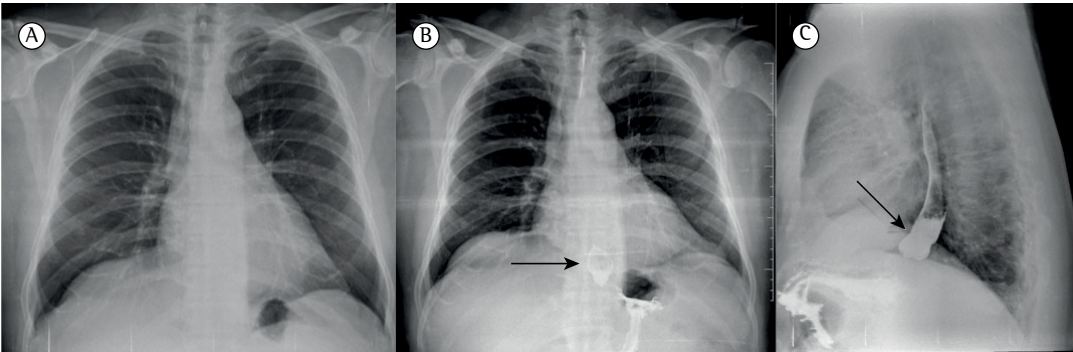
Chest X-rays of a 47-year-old man with a 3-month history of chronic cough. In A, a posteroanterior chest X-ray showing no significant alterations. In B and C, chest X-rays taken after barium swallow and showing a diverticulum in the mid-esophagus (black arrow) that was diagnosed as a traction diverticulum caused by tubercular scarring in the perihilar lymph nodes.
